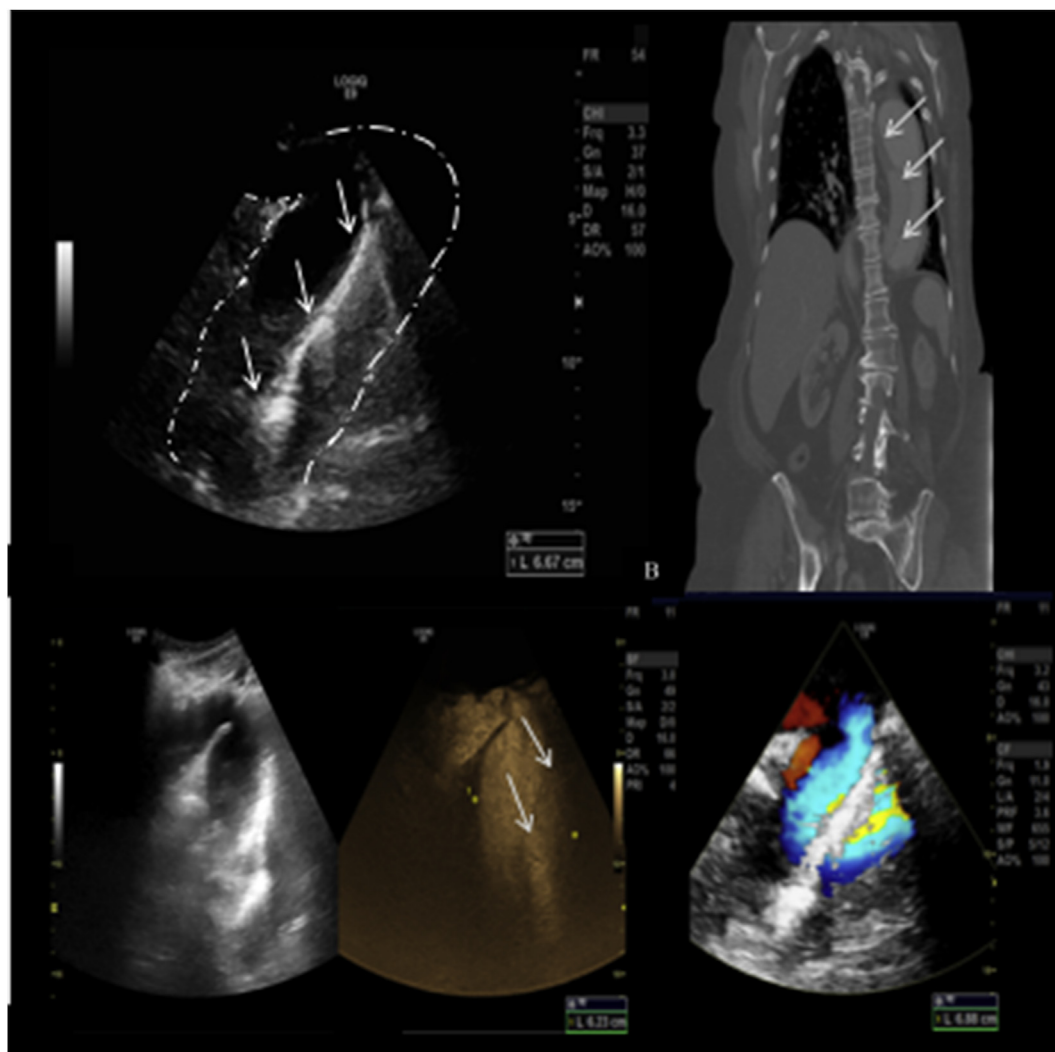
Aneurysms of the distal arch and proximal descending aorta. (A) Fusiform aneurysm of the proximal descending aorta with evidence of chronic dissection (white arrows) both confirmed on CT scan (B). The dissection may be easily overlooked when calcified and when mural thrombus is present, thus misleading the sonographer into thinking that the aorta is of normal calibre (dotted lines indicates the true dimensions of the aorta). In these circumstances, the aneurysm may be better visualised by using a curvilinear transducer (5 MHz) and with B-flow imaging as shown in this example (C) or by using other colour flow modalities (D). Colour Doppler imaging can also be used to better understand the distribution of the aneurysm. However, this may override the arterial borders, hence careful use with B-mode imaging is recommended.
